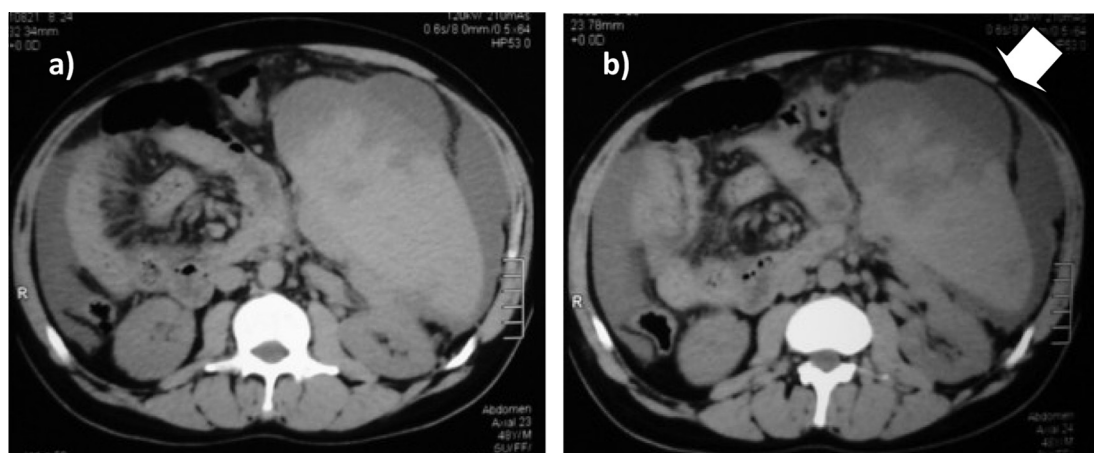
Unenhanced CT scan for the upper abdomen 1 week after the 2nd session of PSE showing splenic infarctions with subcapsular collection along the anterolateral surface of the spleen. Also note mild ascites seen in the perisplenic space and right paracolic gutter which was newly developed in this patient.
